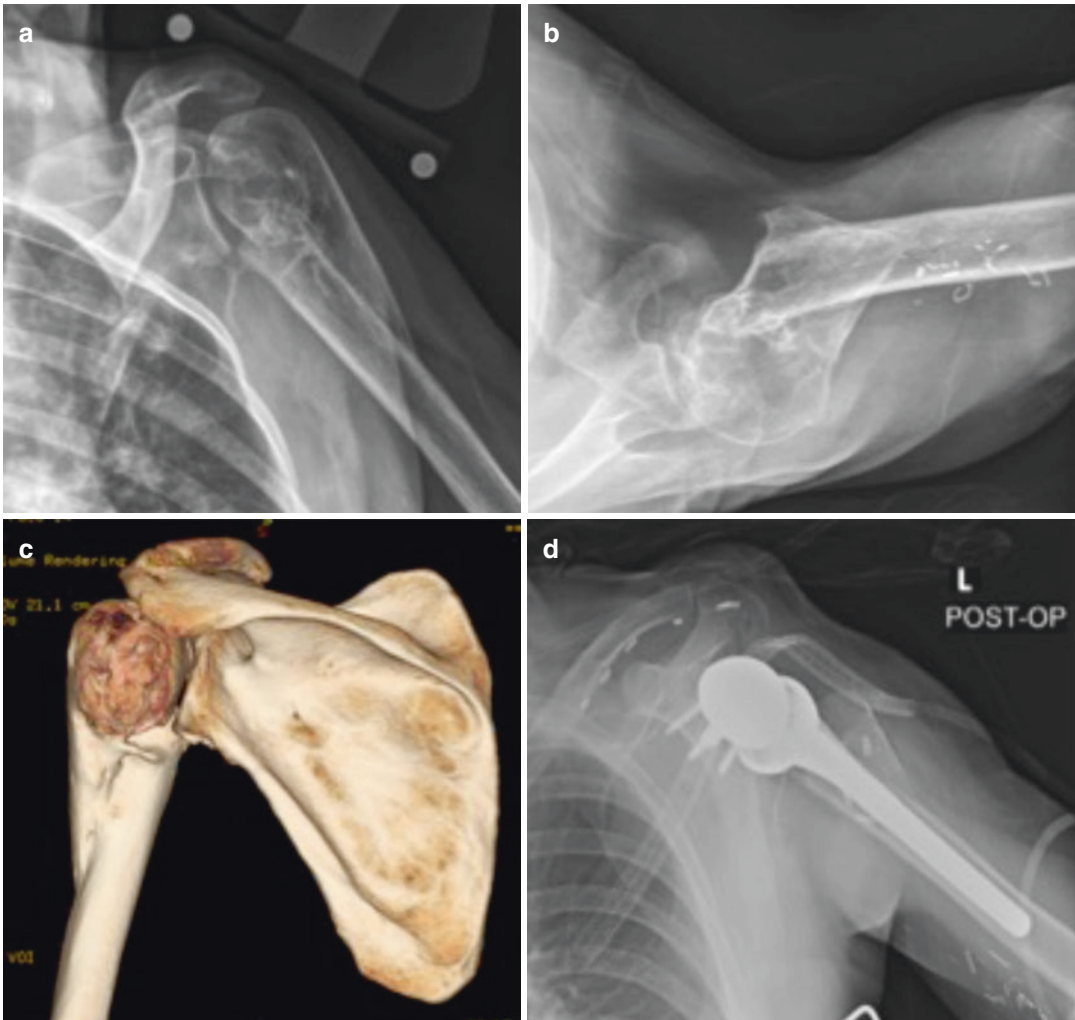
Patient with proximal humerus malunion and deltoid palsy who was reconstructed with pedicled pectoralis major tendon and reverse shoulder arthroplasty. (a) Anteroposterior radiograph of the left shoulder showing proximal humerus malunion. (b) Axillary radiograph of the left shoulder showing proximal humerus malunion. (c)
